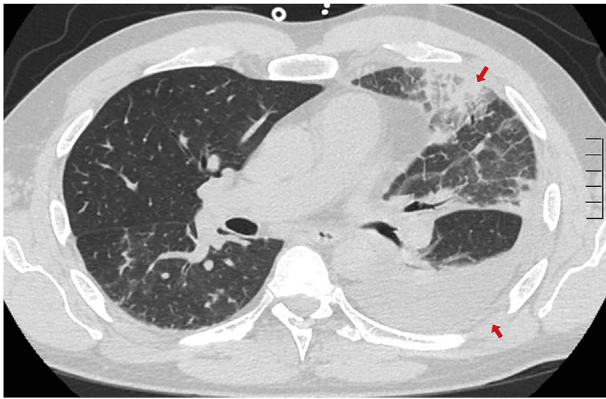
CTA at initial presentation (January 2017).
